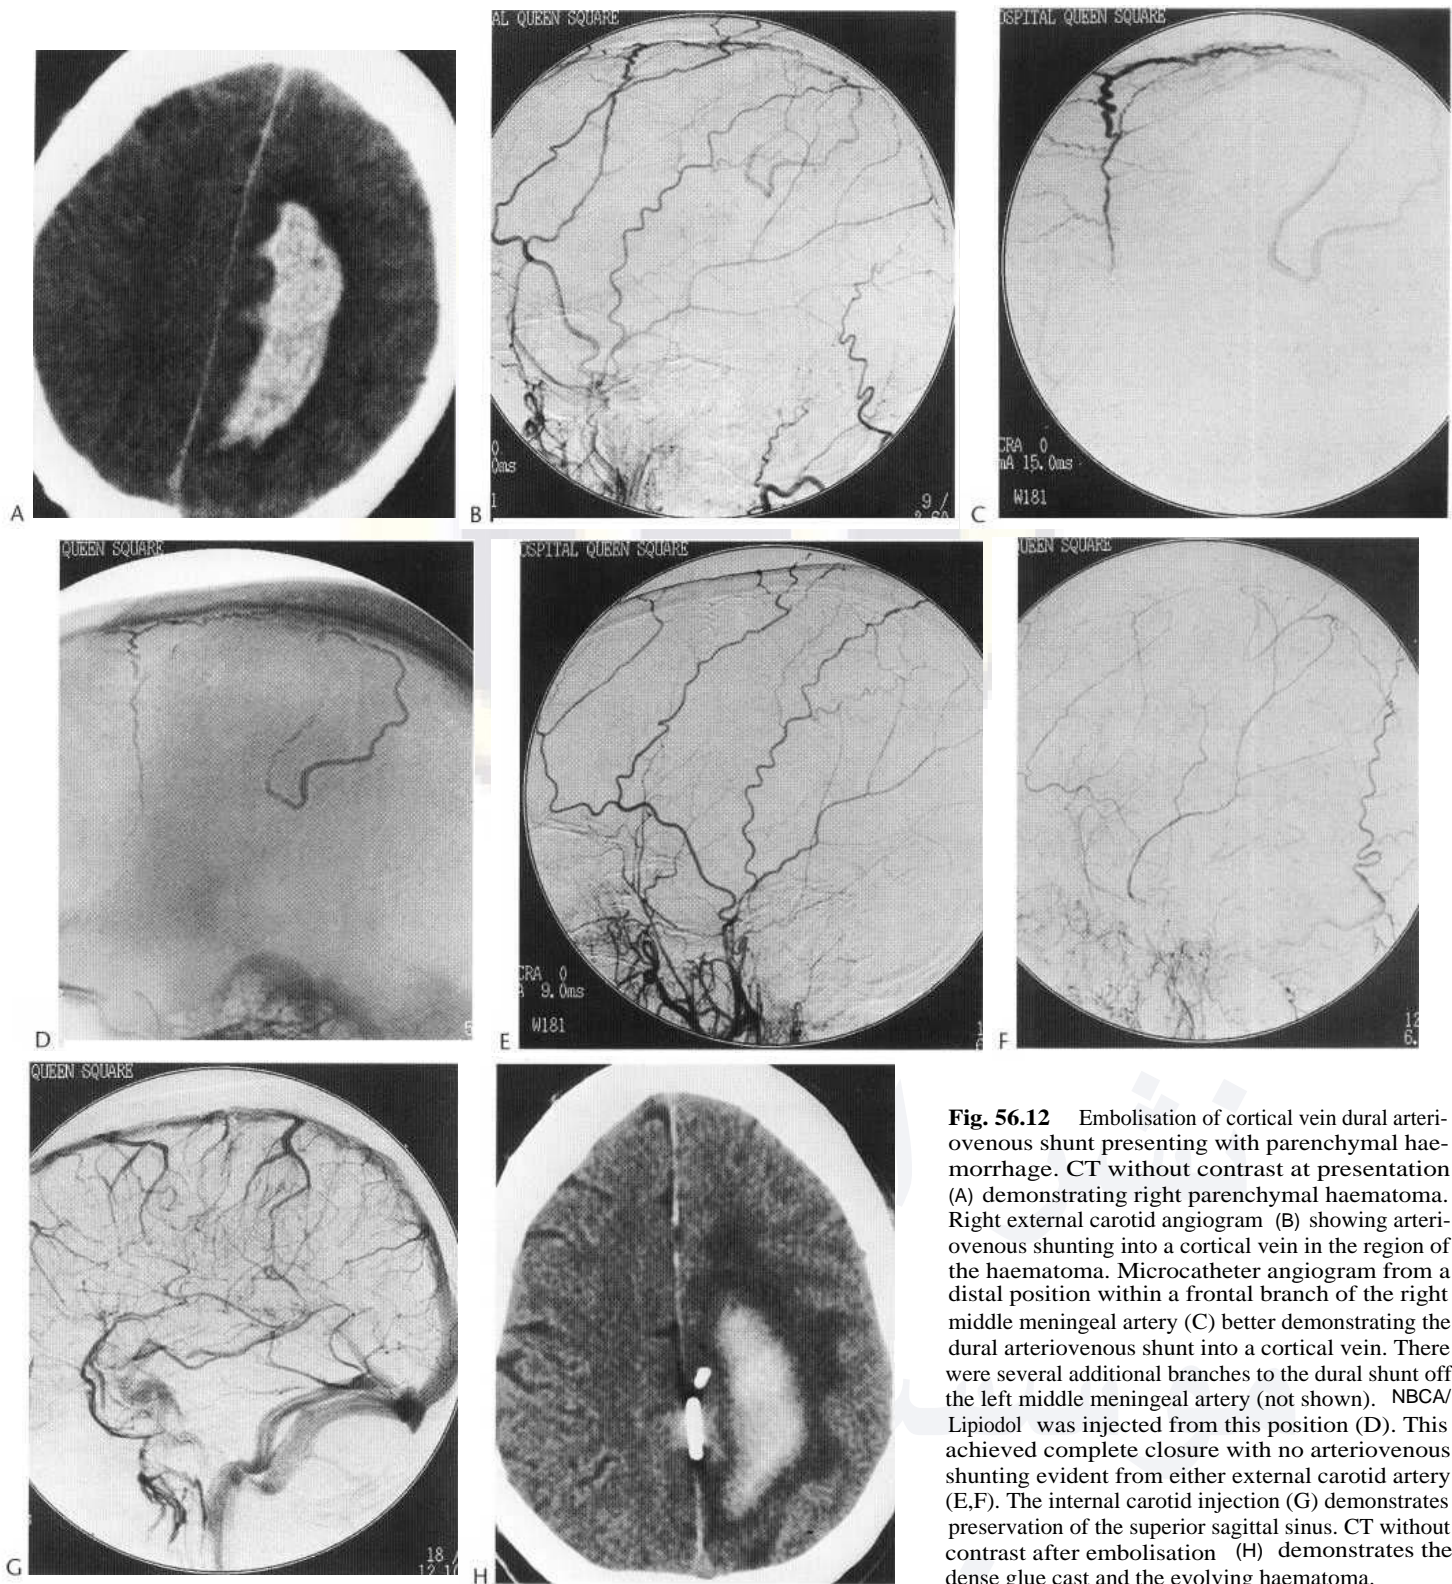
Embolisation of cortical vein dural arteriovenous shunt presenting with parenchymal haemorrhage. CT without contrast at presentation (A) demonstrating right parenchymal haematoma. Right external carotid angiogram (B) showing arteriovenous shunting into a cortical vein in the region of the haematoma. Microcatheter angiogram from a distal position within a frontal branch of the right middle meningeal artery (C) better demonstrating the dural arteriovenous shunt into a cortical vein. There were several additional branches to the dural shunt off the left middle meningeal artery (not shown). NBCA/Lipiodol was injected from this position (D). This achieved complete closure with no arteriovenous shunting evident from either external carotid artery (E,F). The internal carotid injection (G) demonstrates preservation of the superior sagittal sinus. CT without contrast after embolisation (H) demonstrates the dense glue cast and the evolving haematoma.
